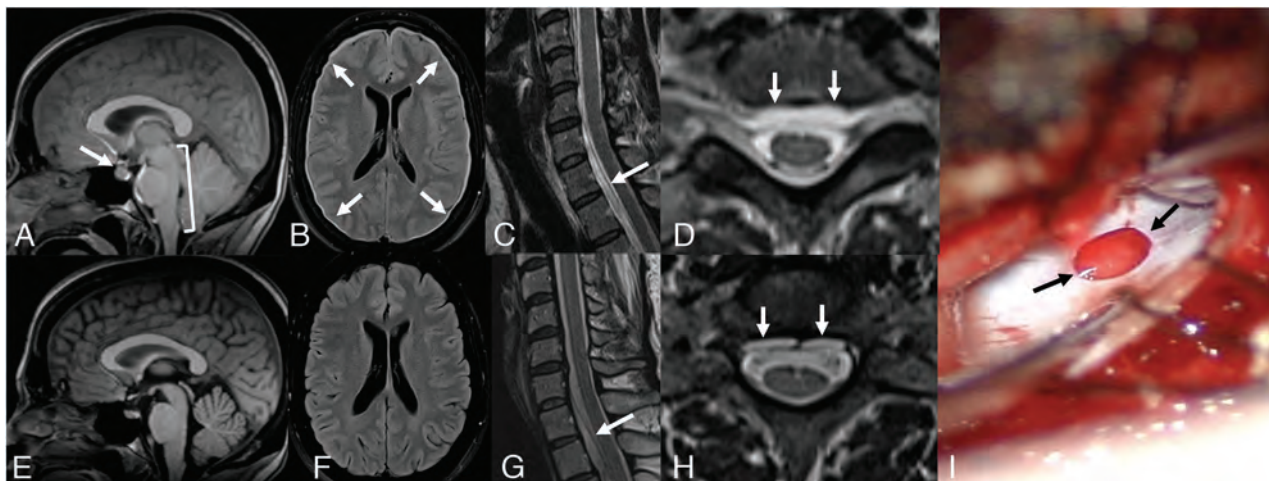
Normalization of MR imaging findings across time despite persistent spinal CSF leaks. A, Sagittal T1 noncontrast MR imaging in 2018 demonstrates sagging of posterior fossa structures (*bracket*), engorgement of the pituitary gland, and narrowed suprasellar distance (*arrow*). B, Axial FLAIR MR imaging in 2018 demonstrates a diffuse, thin subdural collection (*arrows*). Sagittal (C) and axial (D) T2 MR imaging of the cervical spine in 2018 shows a cervicothoracic ventral epidural fluid collection (*arrows*). The patient underwent a dorsal nontargeted epidural blood patch in 2018 with partial relief of symptoms. E, Sagittal T1 noncontrast MR imaging in 2023 demonstrates resolution of brain sag, pituitary engorgement, and narrowing of the suprasellar interval. F, Axial FLAIR MR imaging in 2023 with resolution of the subdural collection. Sagittal (G) and axial (H) T2 MR imaging of the cervical spine in 2023 shows persistence of the cervicothoracic ventral epidural fluid collection. I, Intraoperative photograph later in 2023, with a ventral dural defect identified at T2–T3 (*arrows*). After repair, the patient had substantial symptom improvement, with the Headache Impact Test score improving from 68 to 48 (Headache Impact Test: range, 36–78).
